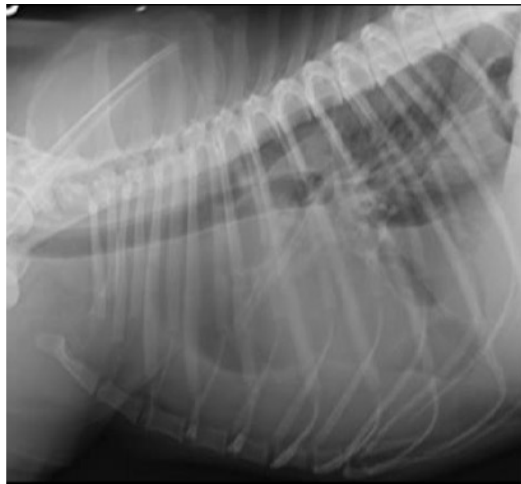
Left lateral thoracic radiography
